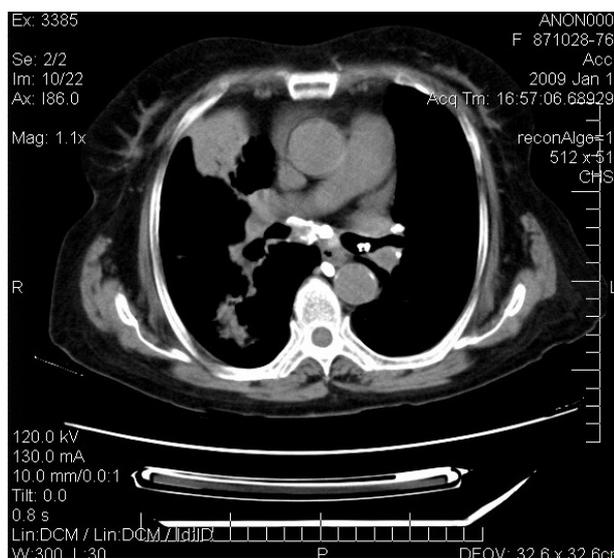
CT scan of the patient with anthracosis and tuberculosis showed right lung infiltration, mediastinal calcification and a calcified Intra-bronchial object in the left main bronchus.
